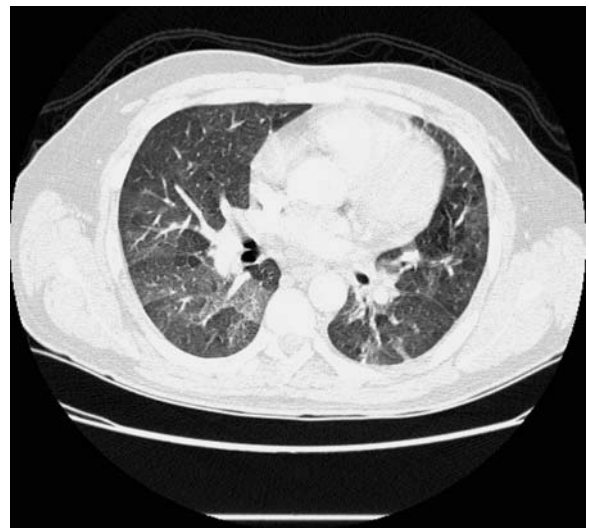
Strongyloides* in a 36-year-old man. Chest CT scan (collimation 16×1.25 mm) shows nonspecific bilateral areas of ground-glass opacity
